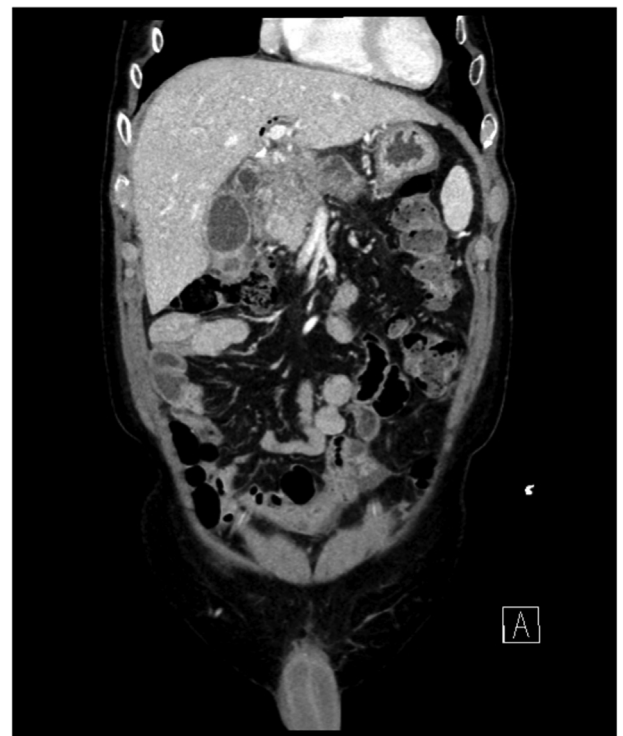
Coronal CT image demonstrating a distended gallbladder with wall hyperemia and a small adjacent abscess consistent with cholecystitis, the head of pancreas mass, and the metal biliary stent.
